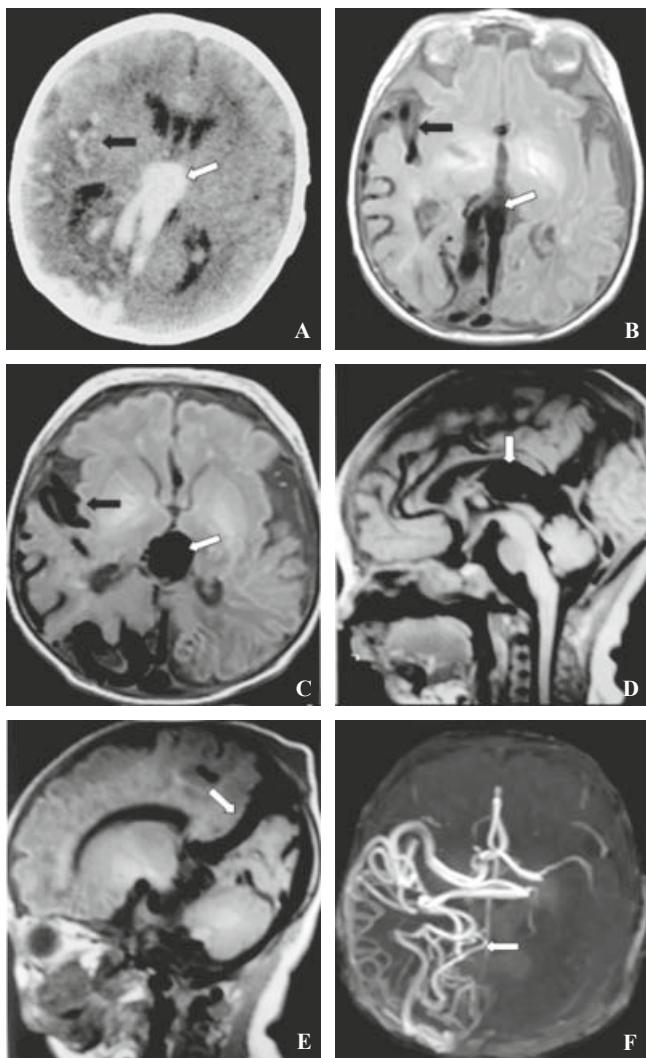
Persistent falcine sinus associated with aneurysmal dilatation of the vein of Galen and arteriovenous malformation. A: Brain CT showing a markedly dilated vein of Galen (white arrow) and dilated vessels in the right Sylvian fissure (black arrow). B, C, D: Brain MRI showing dilatations of the vein of Galen (white arrow) and arteriovenous malformation (black arrow) in the right hemisphere. The straight sinus is patent and has a terminal stenosis. E: Brain MRI showing a persistent falcine sinus (white arrow) reaching the superior sagittal sinus in its posterior third. The patent straight sinus is associated with terminal stenosis. F: Brain MRA showing arteriovenous malformation (white arrow).
